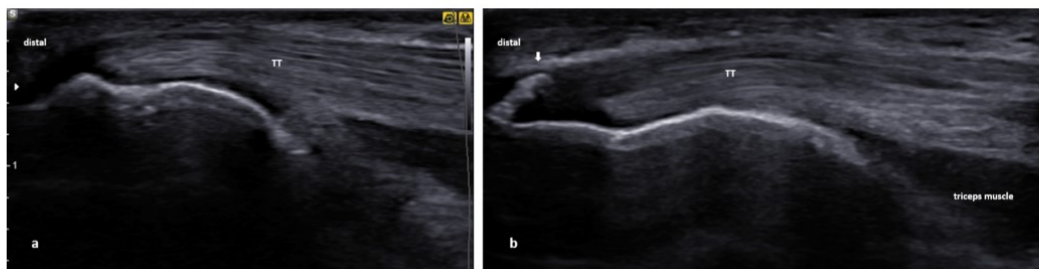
Ultrasound images of the distal triceps tendon (TT): (a) normal longitudinal image of the TT; (b) US image that demonstrates a prominent spur (white arrow) at the olecranon's TT insertion site.
